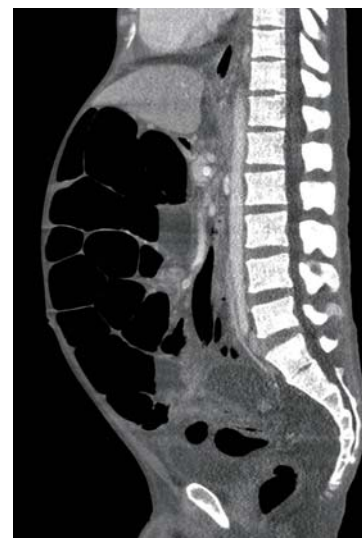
Sagittal contrast-enhanced computed tomography of the abdomen after 6 weeks of tuberculostatic treatment followed by administration of prednisolone. The scan shows massively distended loops of large bowel (including the rectum) with no demonstrable mechanical cause. The diagnosis was Ogilvie syndrome in disseminated tuberculosis with involvement of the abdomen. The initially described small-bowel stenosis is no longer apparent.
